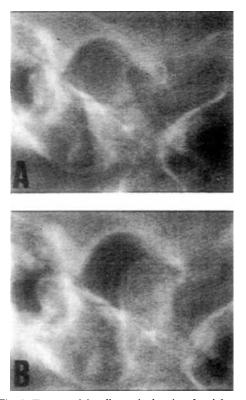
Transcranial radiograph showing the right comdyle in a 19-year-old girl treated for Gaucher's disease at 9 years of age. 2A. In postural position; 2B Maximal opening position. Note the reduced translation movement.
